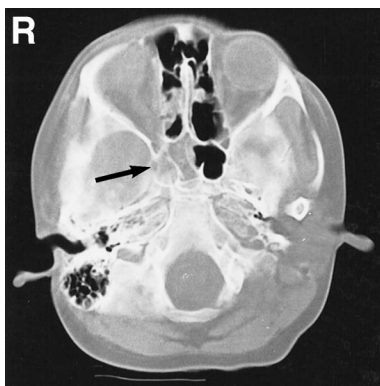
Bone window computed tomography scan on admission showing a bone defect between the temporal base and the sphenoid sinus (arrow).
